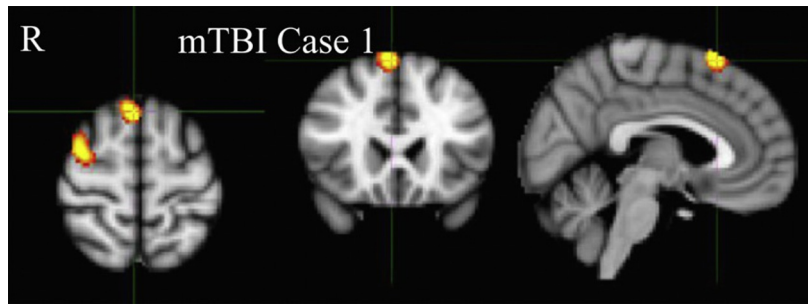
Finding from [Huang et al. \(2014\)](#) demonstrating regions of slow (delta)-wave generation in the superior aspect of the right frontal lobe (yellow), identified using magnetoencephalogram superimposed on T1-weighted magnetic resonance imaging. These regions of delta-wave production may indicate areas of axonal injury. *mTBI*, mild traumatic brain injury. (Reproduced from Huang M-X, Nichols S, Baker DG, et al. (2014) Single-subject-based whole-brain MEG slow-wave imaging approach for detecting abnormality in patients with mild traumatic brain injury. *NeuroImage: Clin* 5: 109–119.)
